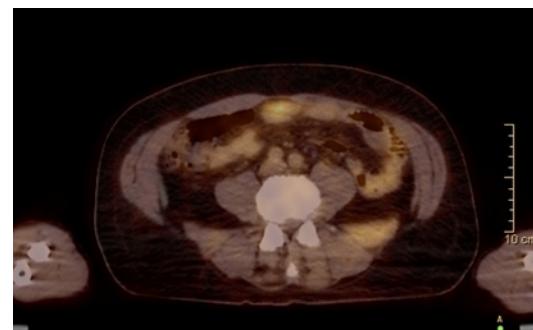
Transverse view of PET CT showing hypermetabolic activity in the peritoneum.
